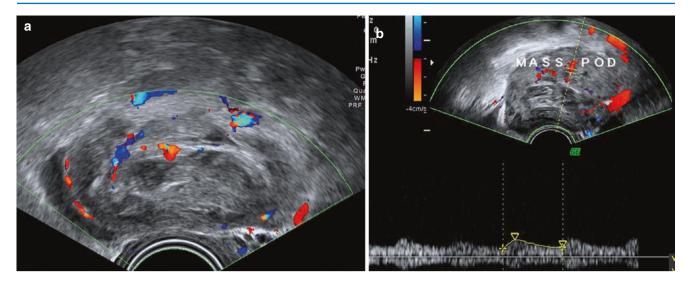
Doppler in complex adnexal masses containing clots in two different patients with ectopic pregnancy. (a) Flow is seen in the tubal walls of the hematosalpinx. (b) Spectral tracing of flow around ectopic tissue in a hematosalpinx
